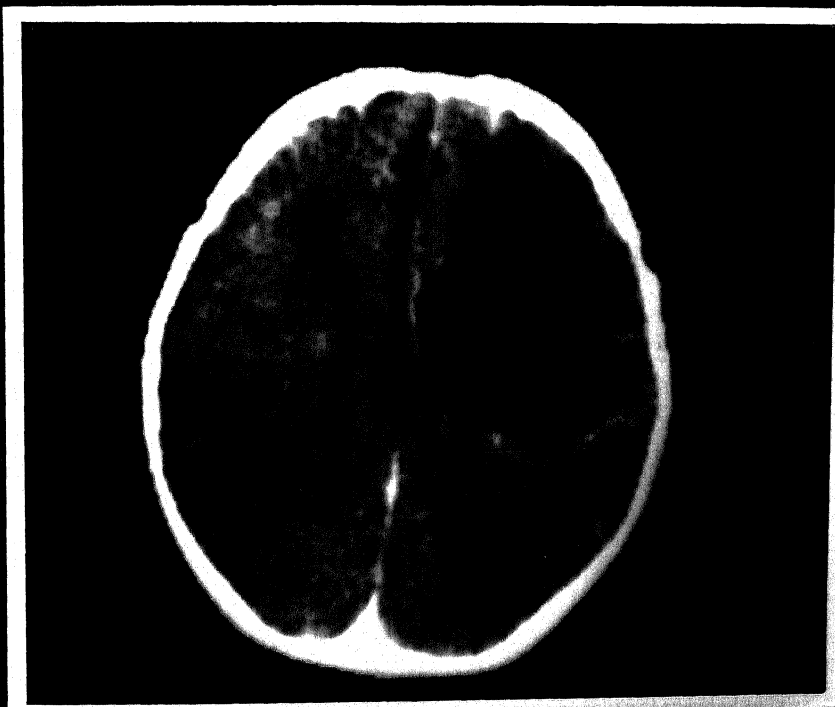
Axial CT section of the above case confirming the diagnosis.
